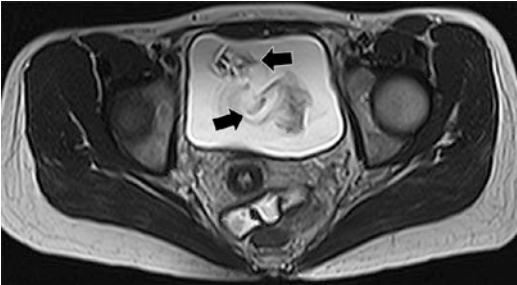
Axial T2-weighted image through the pelvis demonstrates loss of signal (dark) foci within the urinary bladder as a result of fluid shift within, typically related to ureteral jets
